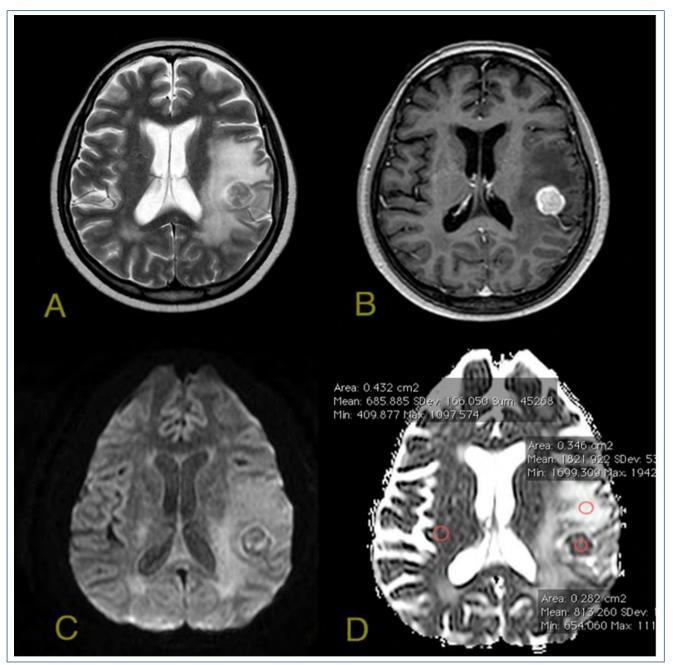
A metastatic lesion in left postcentral gyrus with surrounding vasogenic edema. A) T2-weighted image demonstrates metastatic lesion and peripheral edema. B) The lesion is enhancing heavily in T1-weighted contrast-enhanced images. C) On diffusion-weighted images, the lesion is heterogeneous with a low signal. D) On the apparent diffusion coefficient map, the measurements are obtained by placing regions of interests on the lesion, on the peripheral edema area, and on the contralateral white matter.
